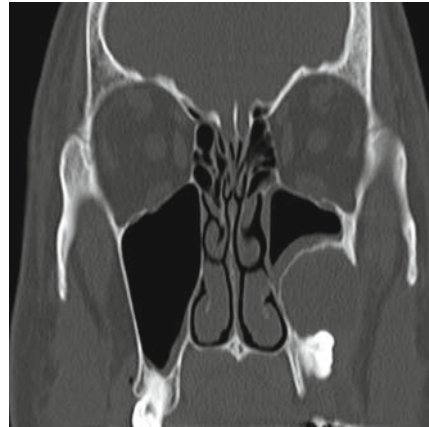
Axial (a) and coronal (b) computed tomography (CT) scanning of a patient with left maxillary sinusitis from odontogenic origin
